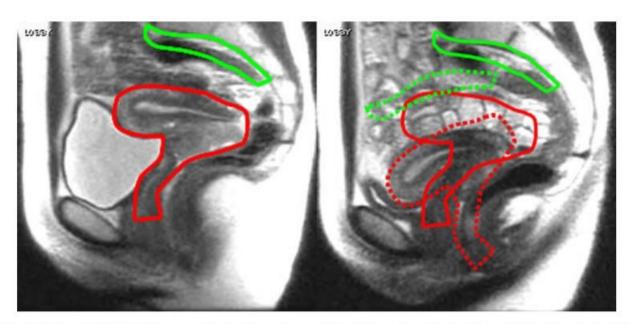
Sagittal T₂-weighted MR images obtained 1 week apart from the same patient, demonstrating the marked difference between uterus and cervix positions, with altered bladder filling. Primary tumor CTV (red contour) and nodal CTV (green) contours overlaid. Solid lines represent targets at week 1, dashed lines represent the targets at week 2 if a direct translational shift is made to compensate for the change in the primary tumor CTV position. Nodal CTV and portions of tumor CTV in week 2 are missed.
